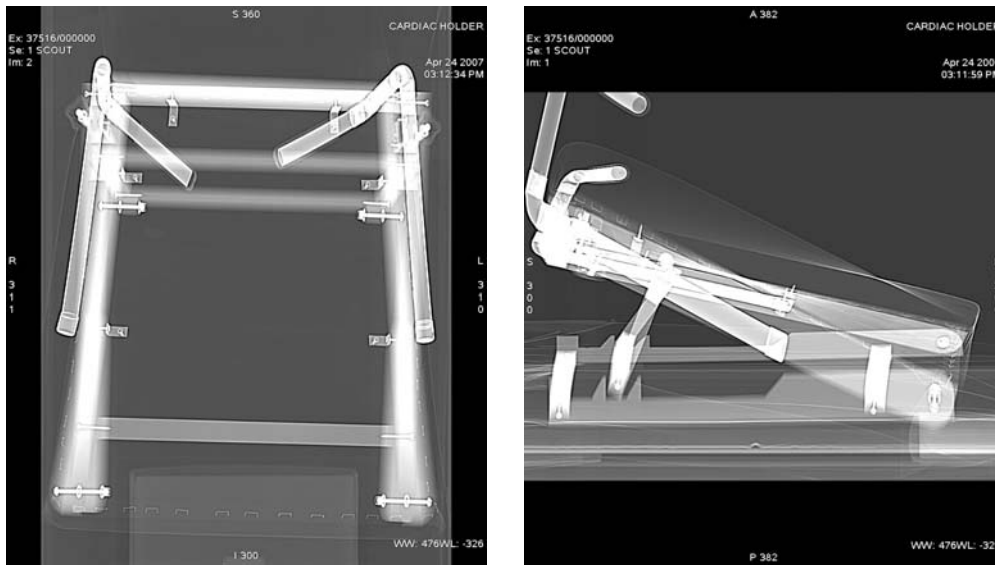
CT images of prototype to test radiolucency of materials.
